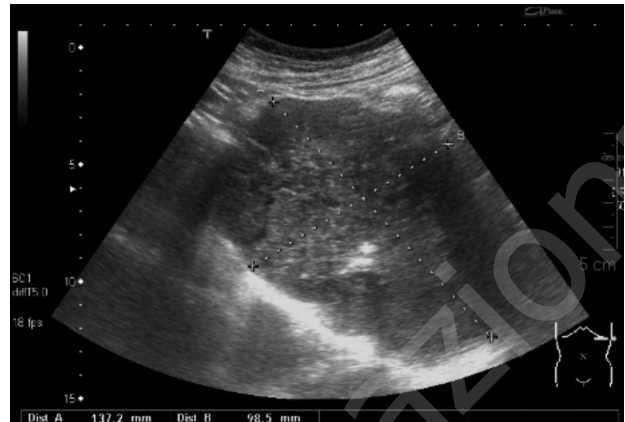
Ultrasounds showed an oval and heterogeneous mass of 13x10 cm in the left hypochondrium.
